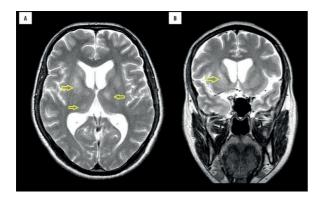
Axial (A) and coronal (B) T2-weighted MRI images showing bilateral hyperintense lesions within the lenticular nucleus, internal capsule, and thalamus (arrows).
